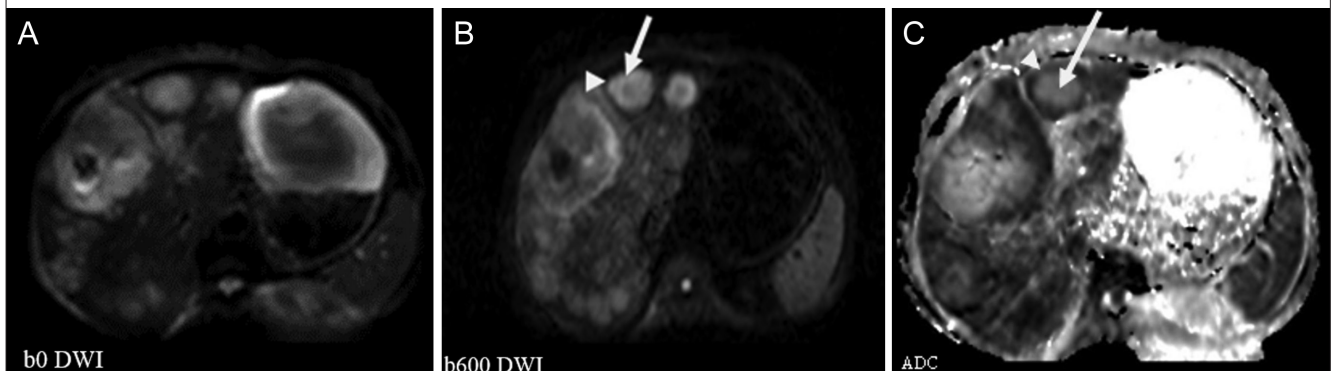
A 68-year-old patient with a gastric adenocarcinoma. There are numerous metastatic lesions in the liver. On DWI, the center of the lesion is hypointense (arrow) and the periphery is hyperintense (arrowhead). In the ADC map, the center has a high value (arrow) and the periphery has a low value (arrowhead). ADC, apparent diffusion coefficient; DWI, diffusion-weighted imaging.
